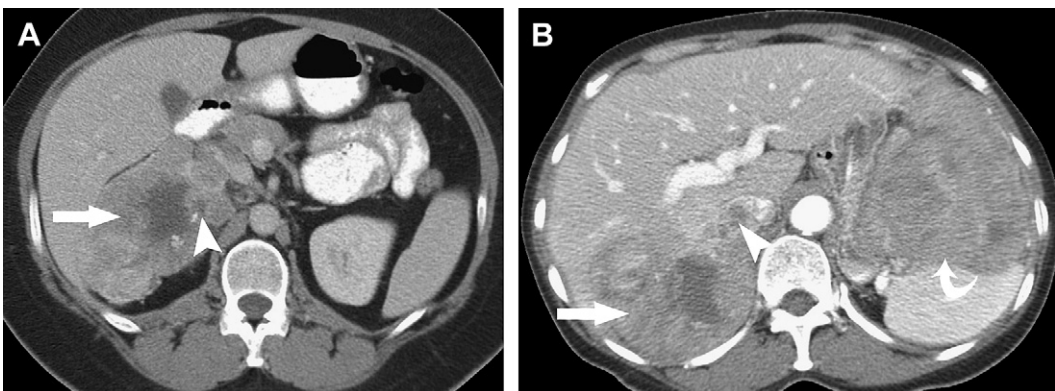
Adrenal carcinoma. (A) Large irregularly enhancing adrenal mass (arrow) on contrast-enhanced CT with evidence of invasion of the IVC (arrowhead) and demonstrated delayed retention of contrast consistent with an adrenal carcinoma. (B) Large irregularly enhancing adrenal mass (arrow) on contrast-enhanced CT with evidence of invasion of the IVC (arrowhead) and left upper-quadrant, large soft tissue mass (curved arrow) representing metastatic disease.
